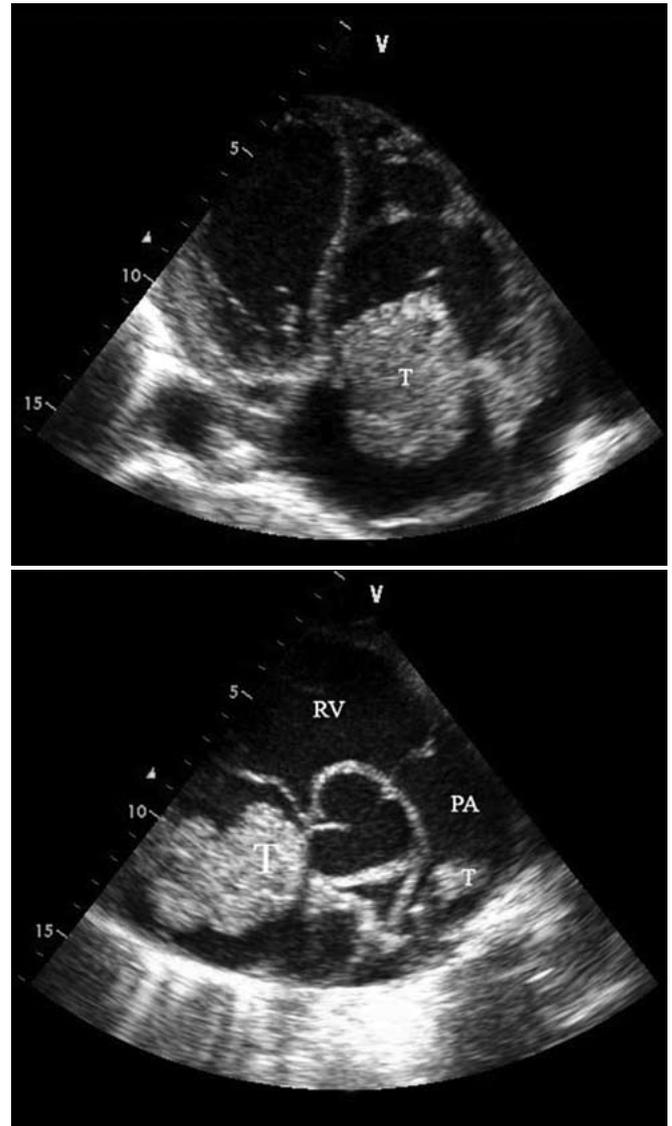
(A) The apical four-chamber view showing a huge thrombus in the right atrium. (B) The parasternal short-axis view showing both thrombi in the right atrium and the main pulmonary artery. RV: Right ventricle; PA: Pulmonary artery; T: Thrombus.
